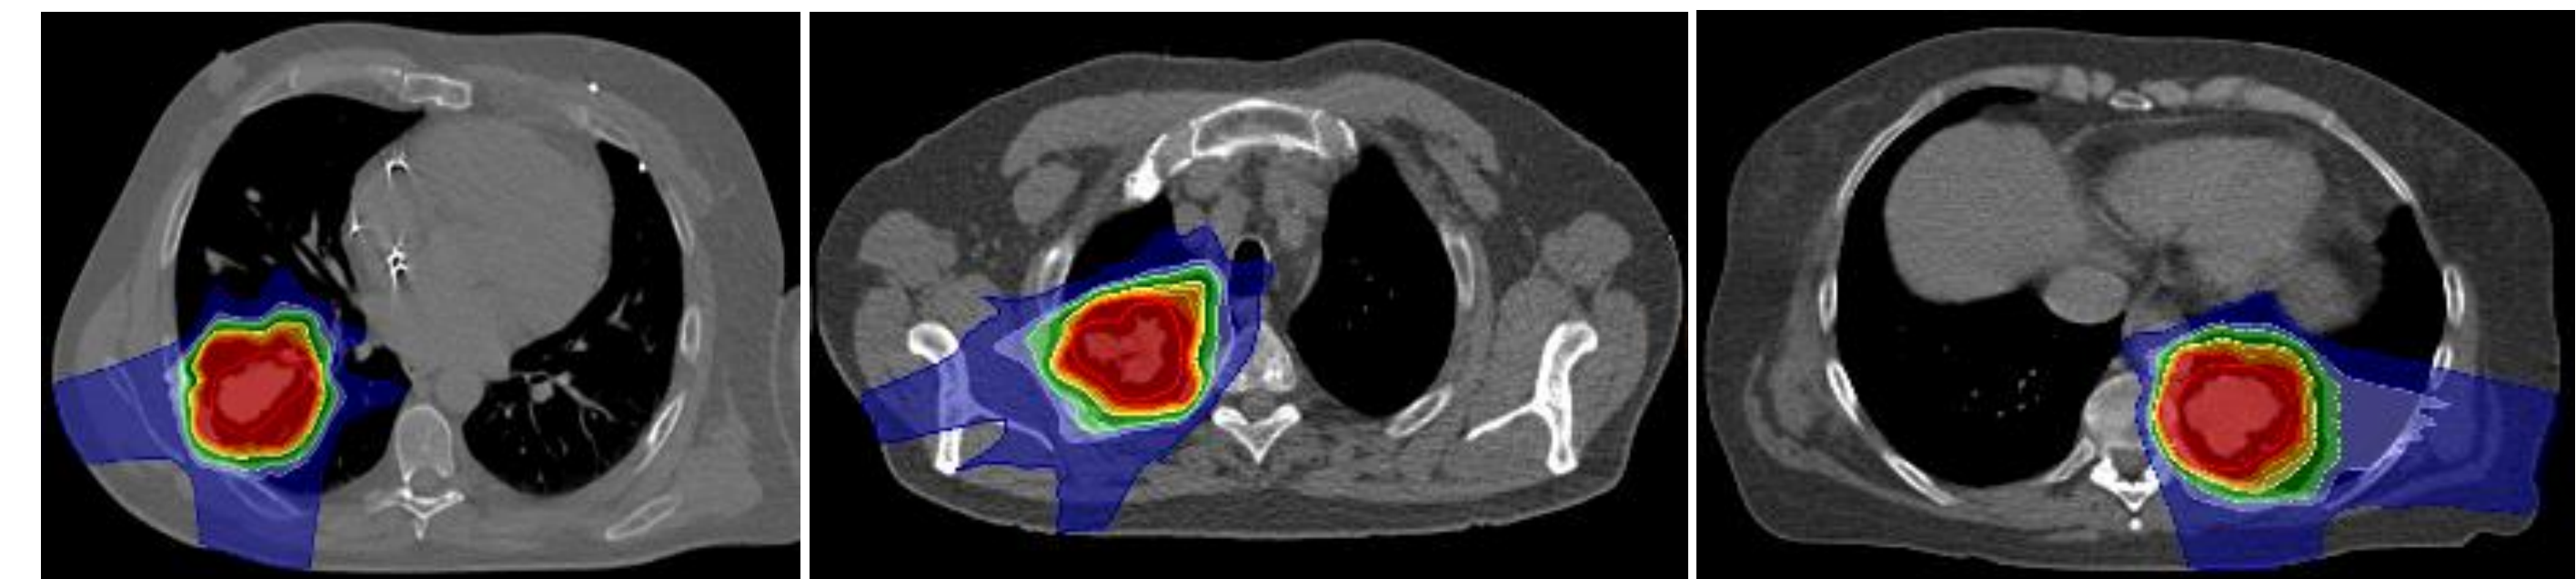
Application of the motion fields onto the CT scans of NSCLC patients, resulting in deformed CTs, after which the doses were recalculated.
